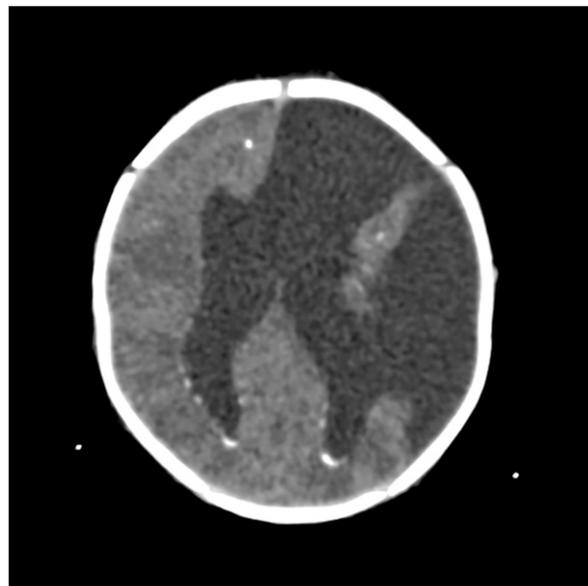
Axial computed tomographic scan of the head without contrast demonstrating periventricular and parenchymal calcifications.
